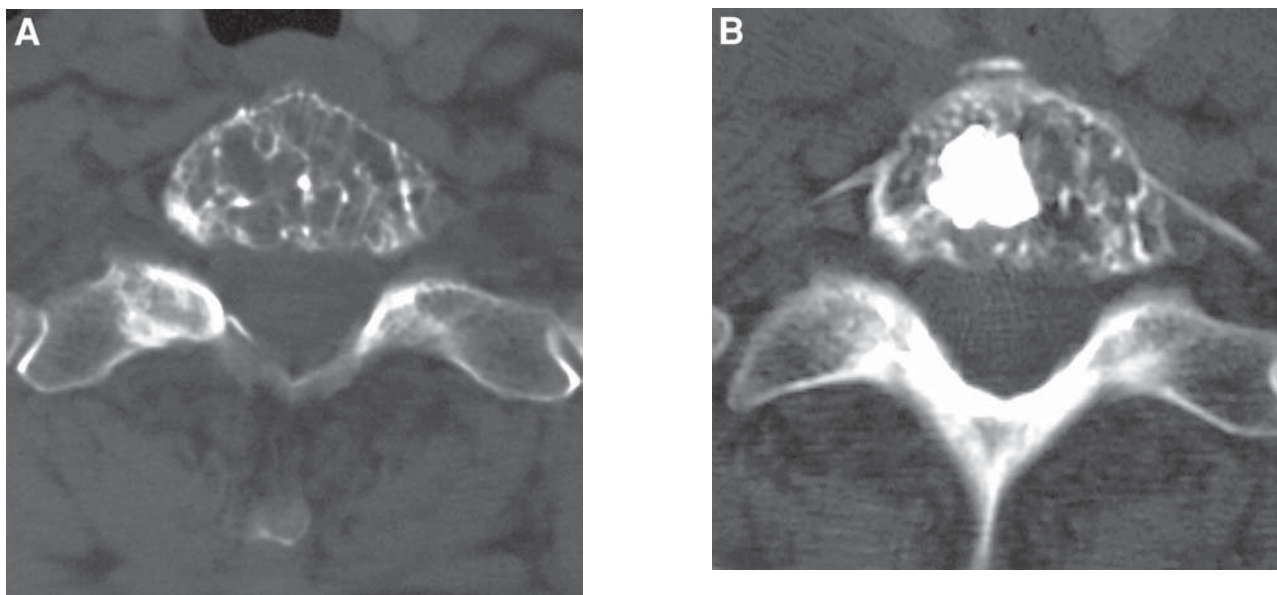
(A, B) Middle-aged woman with a painful C7 hemangioma. CT scan through the affected area shows the typical osteolytic appearance with a “polka-dot” pattern of residual bony struts. Following vertebroplasty, the cement is noted to fill the largest cavity within the vertebral body with no paravertebral extravasation at this level.
